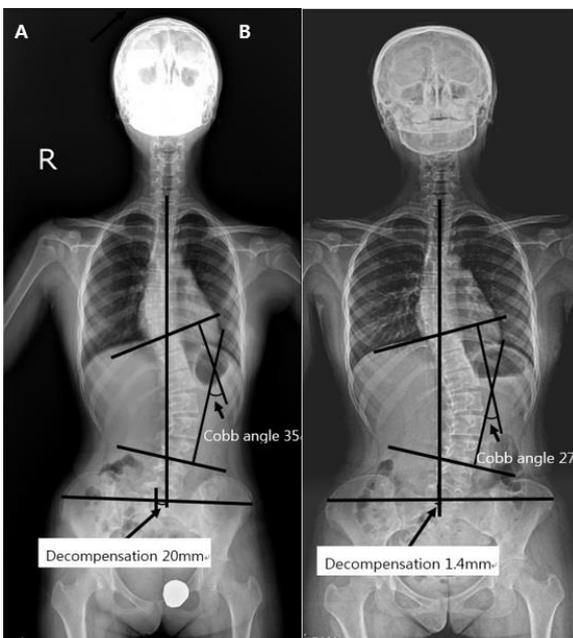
X-ray of patient 1. (A) Before brace (B) After 6 months Boston brace treatment
